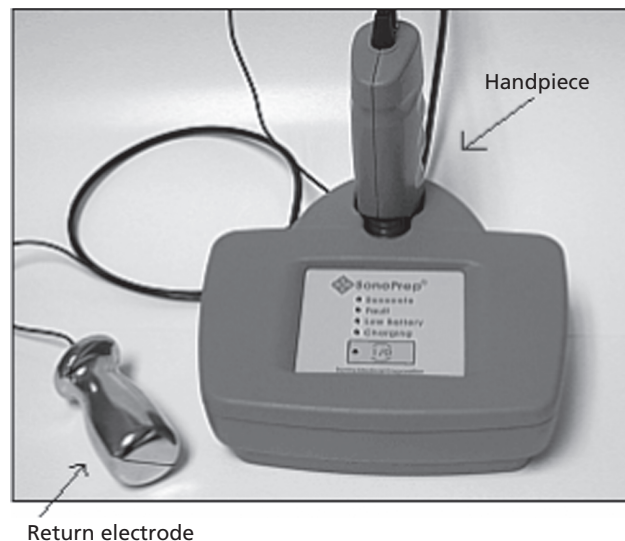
The SonoPrep ultrasonic skin permeation device^[183]
